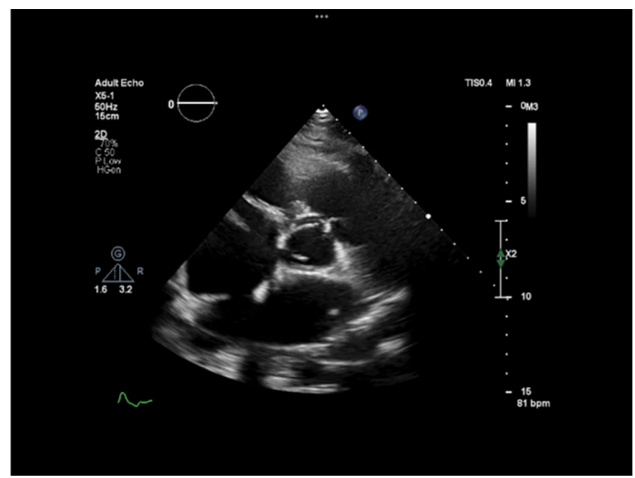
Transthoracic Echocardiography Image Showing Normal Aortic and Pulmonary Valves.
